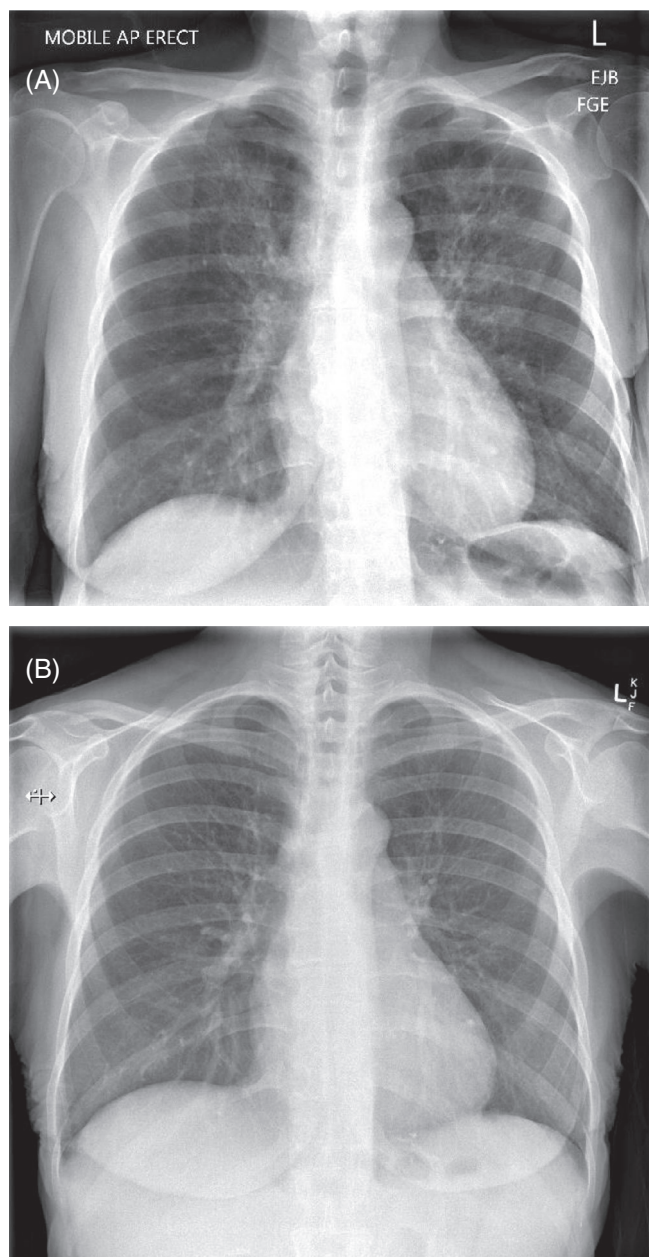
Comparative radiographs taken at (A) time of PJP-IRIS diagnosis with bilateral perihilar consolidation and (B) 5 weeks post treatment, with resolution of changes following corticosteroid treatment.
